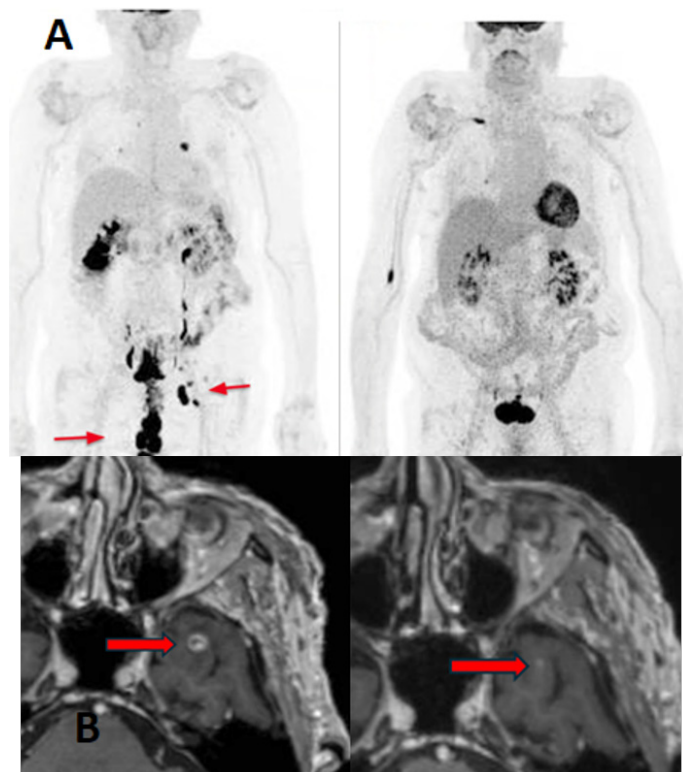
(A) MIP (Maximum Intensity Projection) of PET-CT FDG of the complete response before and after T-DXd (B) evolution of one metastasis on brain MRI after 1 cycle of Tdx.
